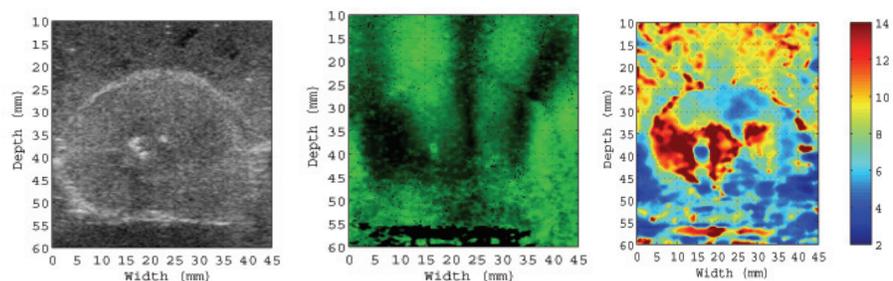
Matched B-mode ultrasound (left), crawling wave sonoelastogram where green corresponds to high vibrational amplitude and vice versa for black (middle), and shear velocity image (right) in prostate.
